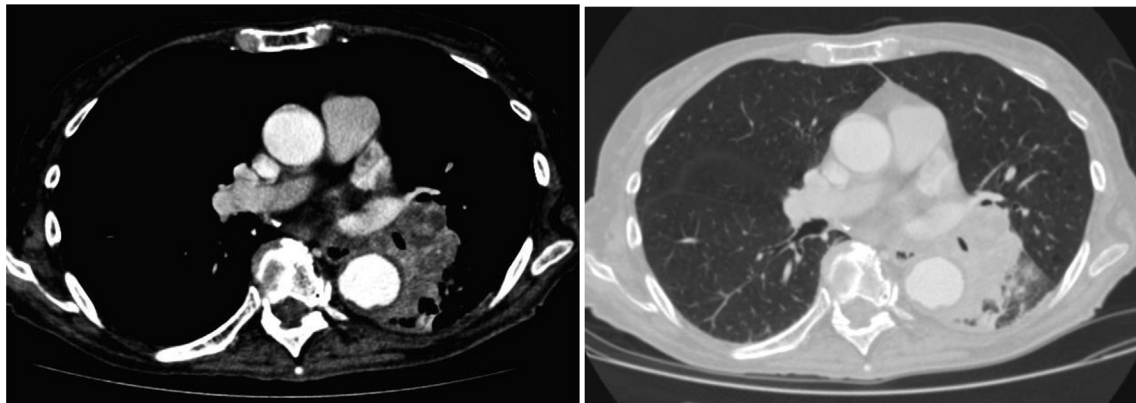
CT images from a 53-year-old man presenting with cough and fever, demonstrating left hilar hypodense lymphadenomegaly and leading to the diagnosis of lymph node tuberculosis.
